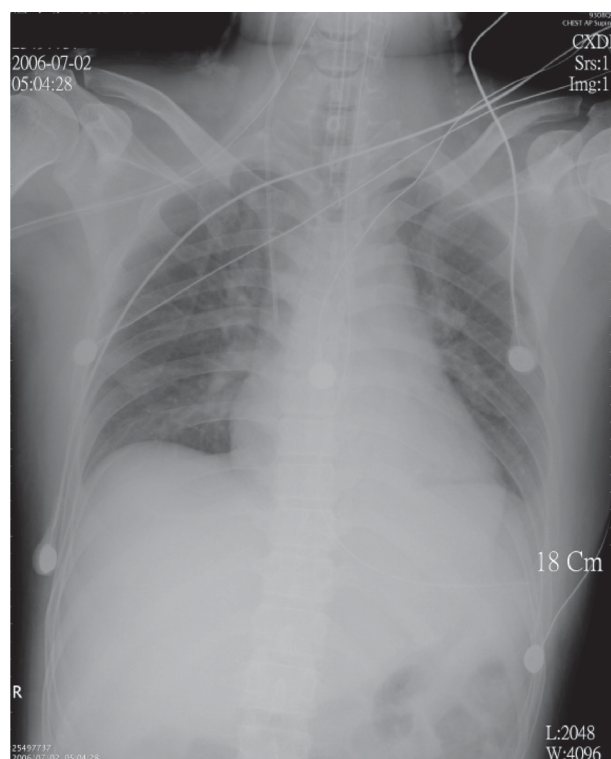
Chest X-ray film showing left pleural effusion and pulmonary edema.
